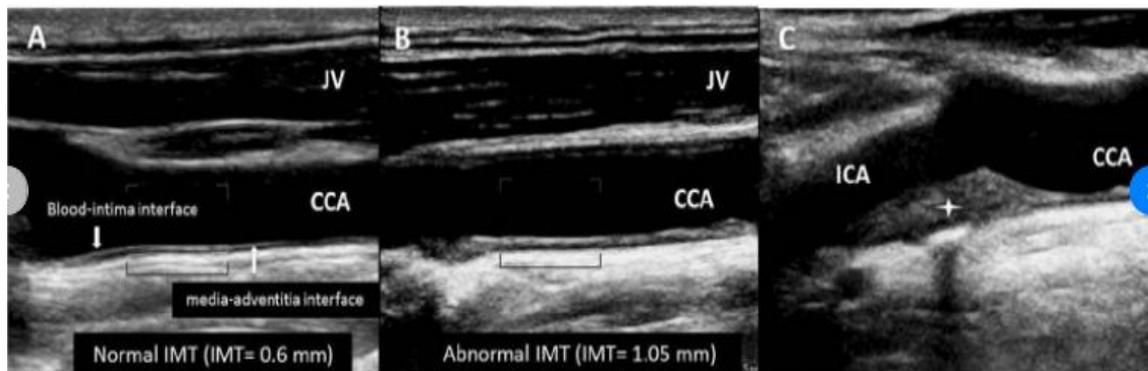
Noninvasive vascular ultrasound of the carotid arteries A)Normal IMT measurement at the posterior level of the common carotid artery B)Abnormal IMT (cut-off value for abnormality >0.9mm) C) Large atherosclerotic plaque at the bifurcation and internal
